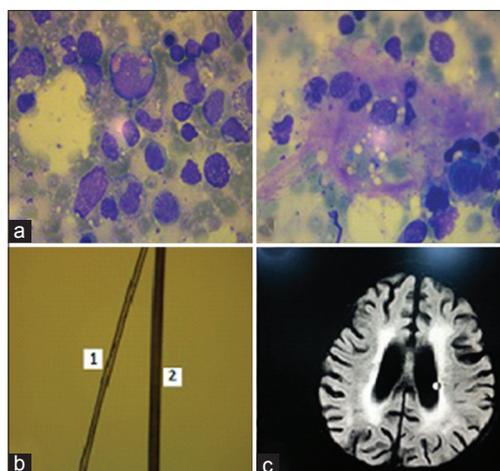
(a) Bone marrow aspirate smears showing giant cytoplasmic granules with in myeloid precursors and hemophagocytosis. (b) 1 patient's hair, 2 Normal hair. (c) Magnetic resonance imaging images show diffuse cerebral atrophy
